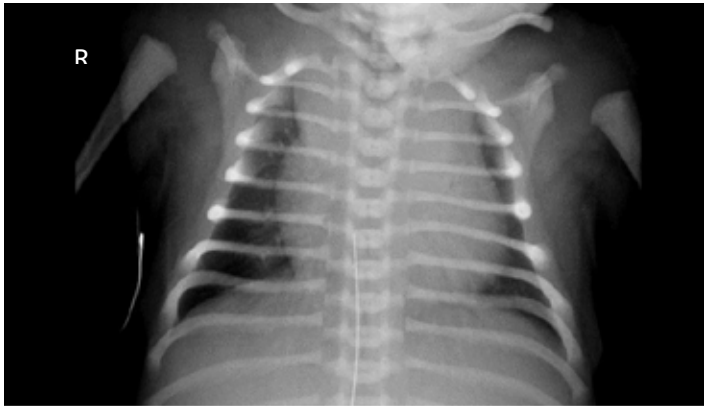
Anterior-posterior chest radiograph of patient showing mild cardiomegaly
